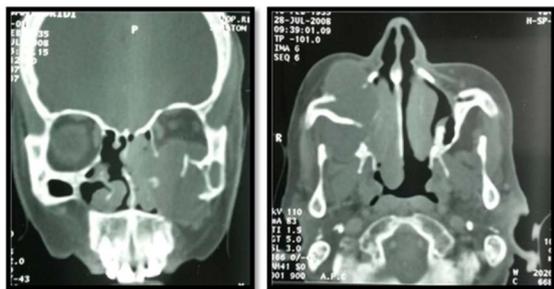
Axial and coronal CT scan imaging demonstrating a mucocele of the right maxillary sinus with important erosion of the adjacent walls and extension to the orbit and infratemporal fossa.
